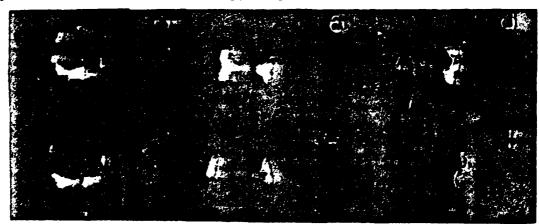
Mr T.J. is a 50-years-old patient with aymptomatic bilateral carotid occlusion. X-ray scan showed moderate cortical atrophy without parenchymal lesions. On IAMP SPECT sections, four areas are hypoactive of which two are shown here, one is left prerolandic (upper images), the other is located in deep right temporal region (lower images). The latter appears extended to T4 and T5. Transverse, frontal and sagittal sections are respectively shown from left to right on this figure.
